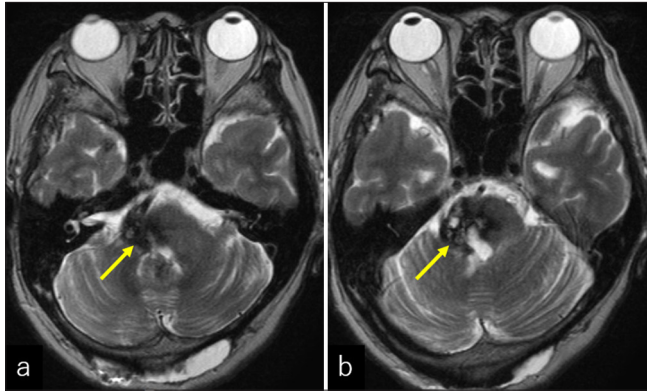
Axial T2-weighted magnetic resonance images at the level of (a) lower and (b) middle pons, performed on postoperative day 30, showing residual lesion (arrow).
